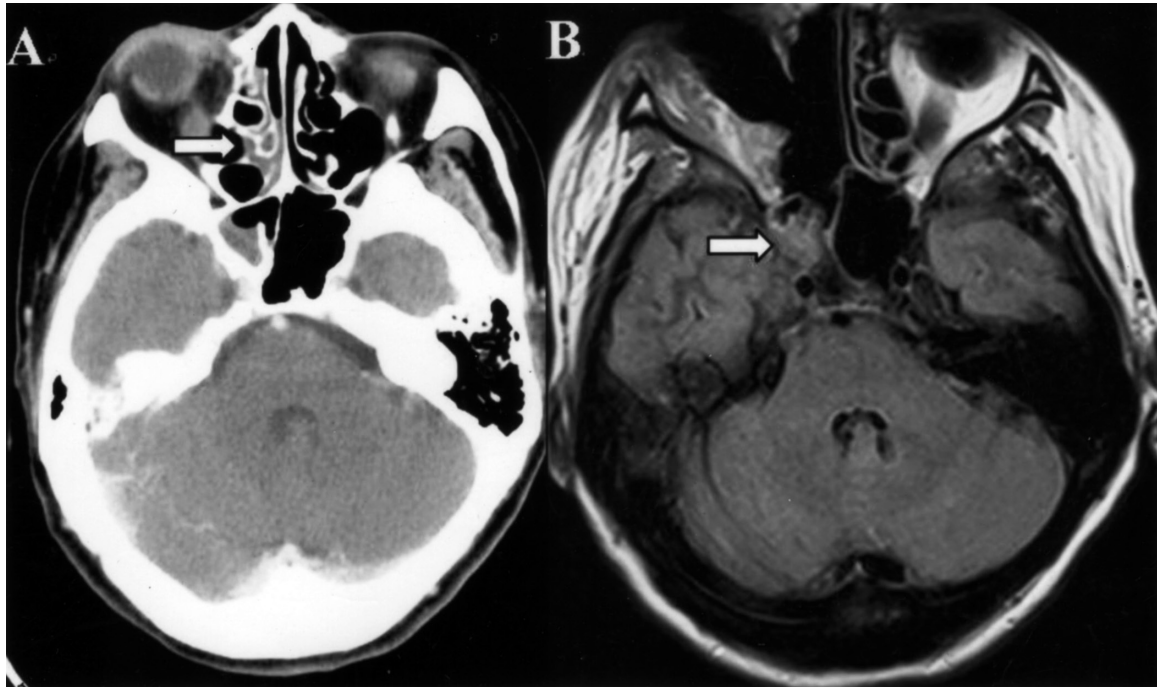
Findings of head imaging examinations before treatment: (A) CT scan of the orbital and paranasal sinuses revealed thickness and good enhancement of the right upper nasopharynx (white arrow). (B) Axial T2-weighted MRI scan showed fungal sinusitis with intracranial parasellar extension (white arrow).
